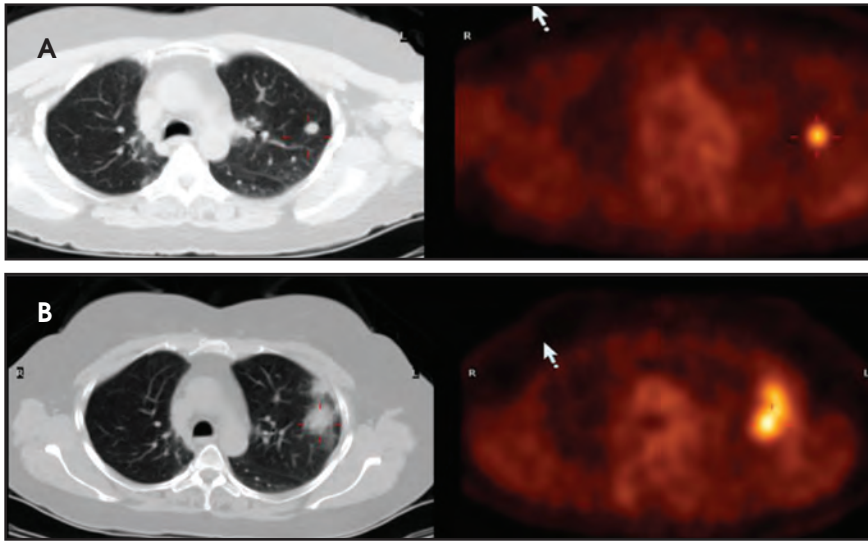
CT and fused PET/CT images (A) pre-SBRT and (B) 3 months post-SBRT. Left upper-lobe lesion appears as patchy consolidation with some surrounding ground-glass opacities, which conformed to the intermediate dose of SBRT.
